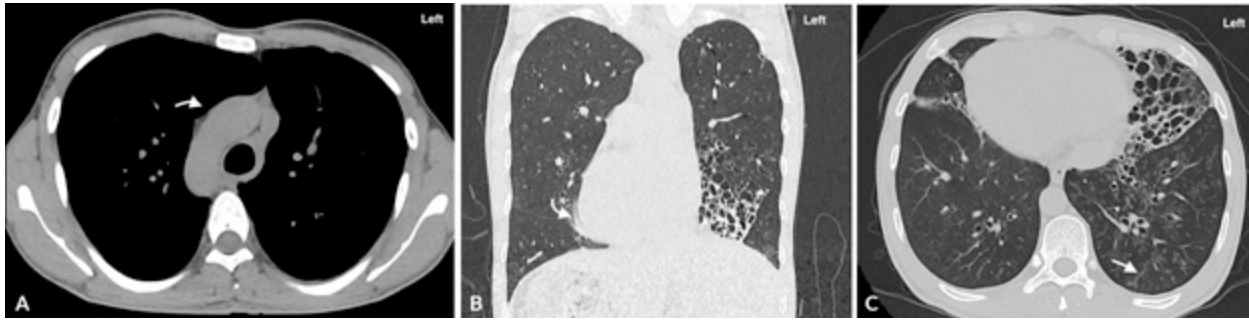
High-resolution computed tomography of the chest on 80-channel tomograph. A) right aortic arch; B) cardiac apex to the right of the midline with multiple cylindrical and sacular bronchiectasis; C) multiple micronodules with a "tree-in-bud" pattern suggesting infection.
